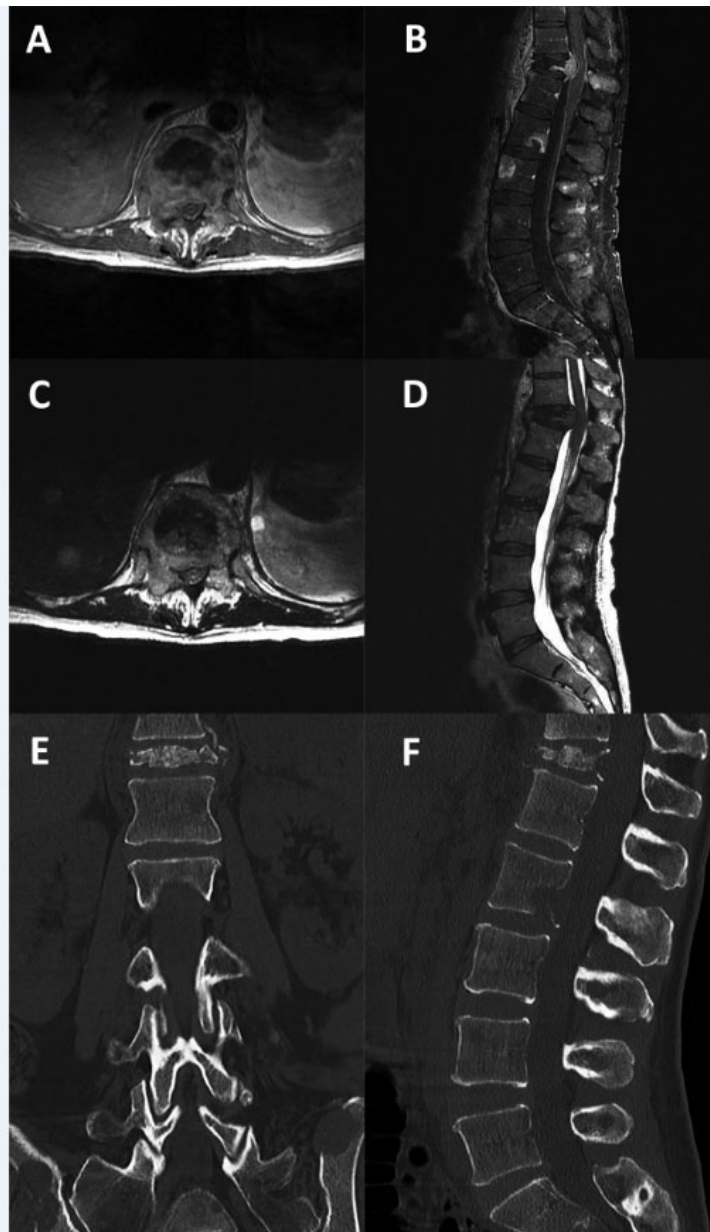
A and B. T1 axial and T1 sagittal MRI with contrast shows an enhancing T12 vertebral body lesion with dorsal extension and compression of the thoracic spinal cord. C and D. T2 axial and T2 sagittal MRI of the thoracolumbar spine demonstrates impaired CSF signal around the spinal cord. E and F. Coronal and sagittal CT of the thoracolumbar spine demonstrates the severe pathologic compression fracture of T12.
